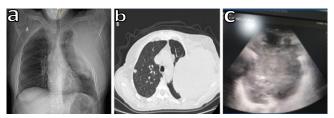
(a) Frontal chest X-ray revealed a water-toned opacity occupying the upper two-thirds of the left lung field, with outer margins merging with the chest wall and extending beyond the limits of the thorax, accompanied by costal lysis on the opposite side. (b) Chest CT scan in the parenchymal window displayed a tumoral mass in the left hemithorax, characterized by soft tissue invasion and costal lysis on the opposite side, along with a nodule in the contralateral lung. (c) Ultrasound examination showed a roughly rounded tumor with irregular contours and a heterogeneous echostructure.
